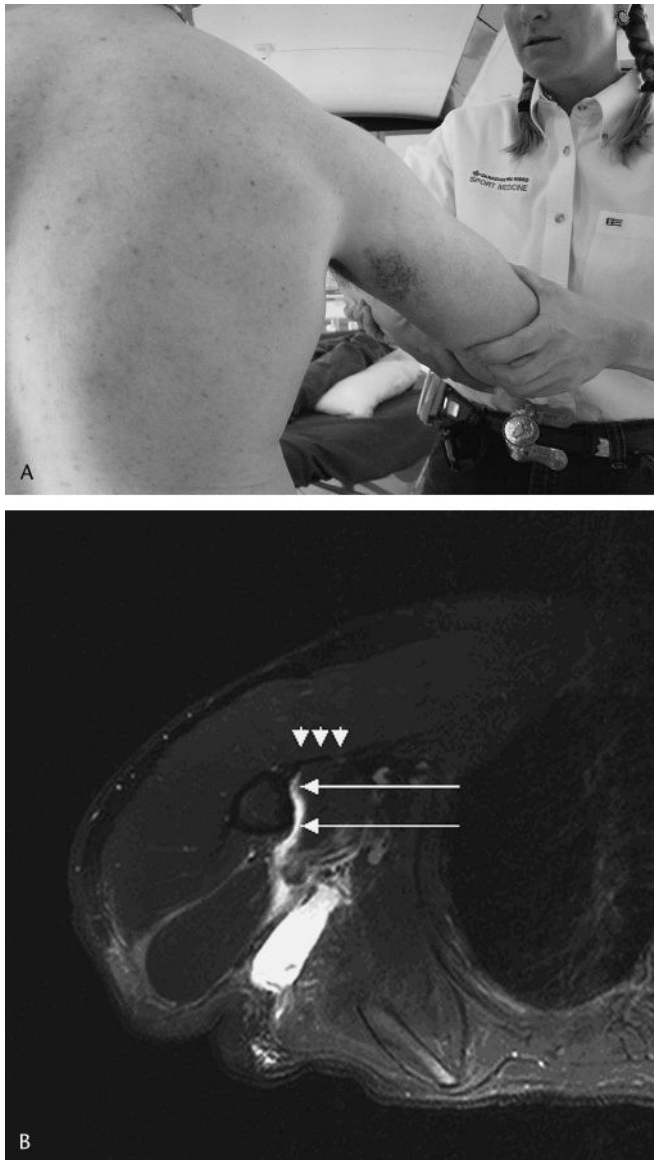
A, Bruising and defect in posterior axillary fold of the injured athlete. B, Axial fat-suppressed T2-weighted image of the right humerus and hemithorax. Note the linear high signal fluid extending along the medial margin of the proximal humerus to the expected insertion site of the latissimus dorsi tendon along the medial margin of the intertubercular groove (long white arrows). The normal-appearing, low-signal-intensity pectoralis major tendon can be followed to its insertion on the lateral margin of the intertubercular groove (white arrowheads).
